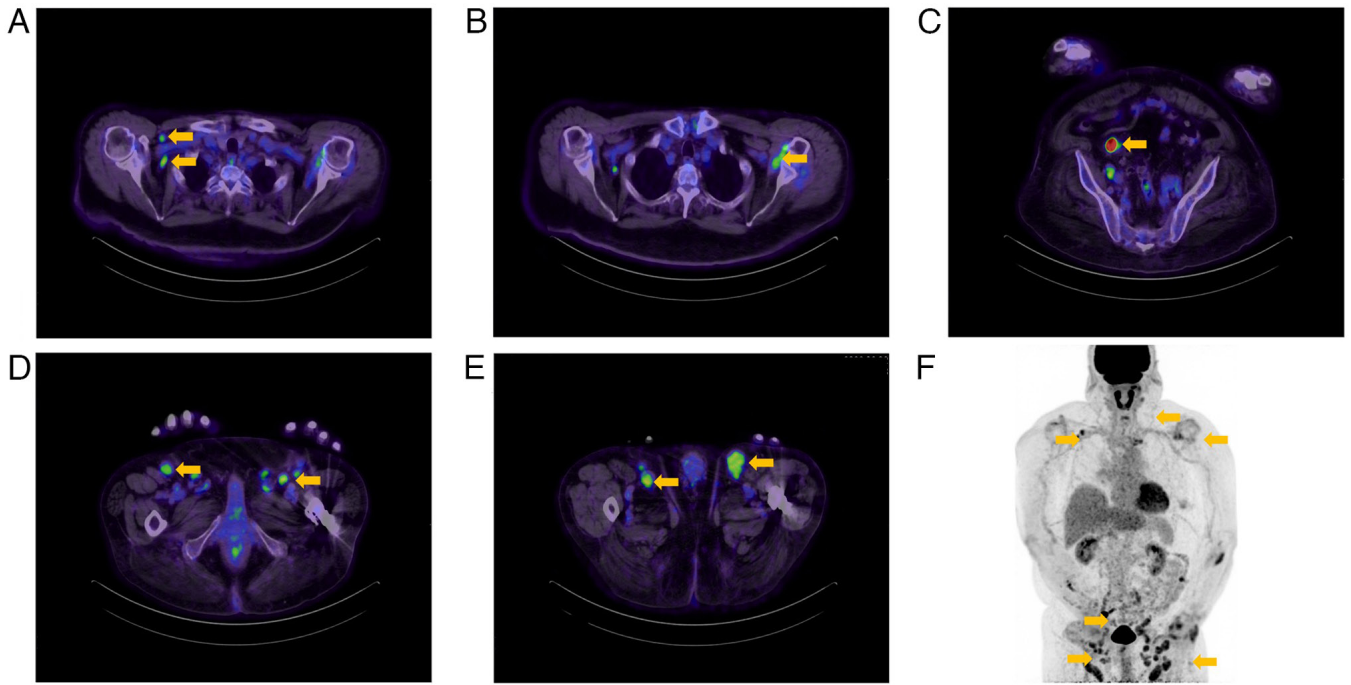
Positron emission tomography/computed tomography images of the trunk. (A-C) Strong FDG accumulation was observed in the bilateral axillary and intraperitoneal lymph nodes. (A) Right axillary lymph nodes. (B) Left axillary lymph node. (C) Intraperitoneal lymph node. (D and E) Abnormal FDG uptake was also seen in the bilateral inguinal lymph nodes. (F) Multiple lymph nodes showed abnormal FDG accumulation.
